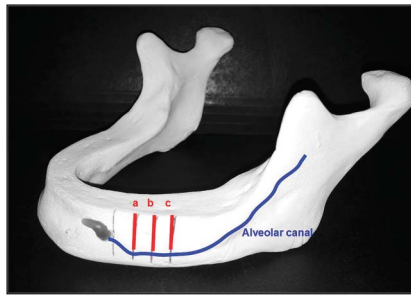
Site used for the assessment of BH and BW. In both sides of each edentulous mandible, the CBCT cross-sections at 6, 11, and 16 mm (site a, b, and c, respectively) posterior to the most distal section including the mental foramen were used for radiographic measurements. According to previous studies, these positions correspond to the second premolar and the mesial and distal roots of the first molar.¹⁹
